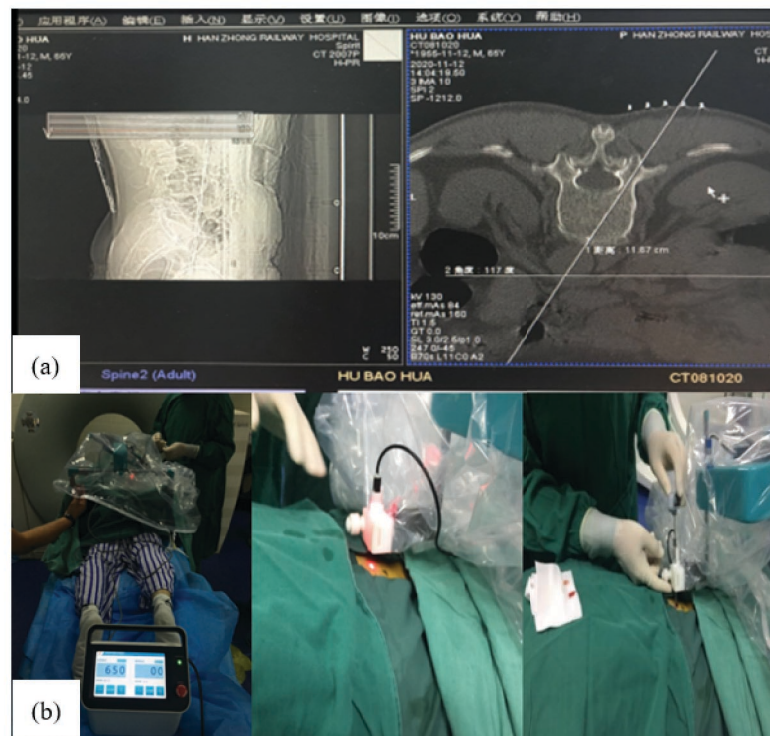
Intraoperative pictures (a) Intraoperative CT images for planning and designing the puncture route (b) 3D coordinate guidance system input data to determine the direction of puncture
